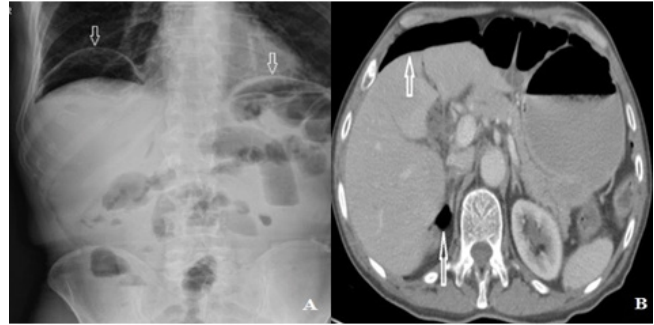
Direct abdominal radiography and tomography images of 35 years female patient. Arrows show free air.
